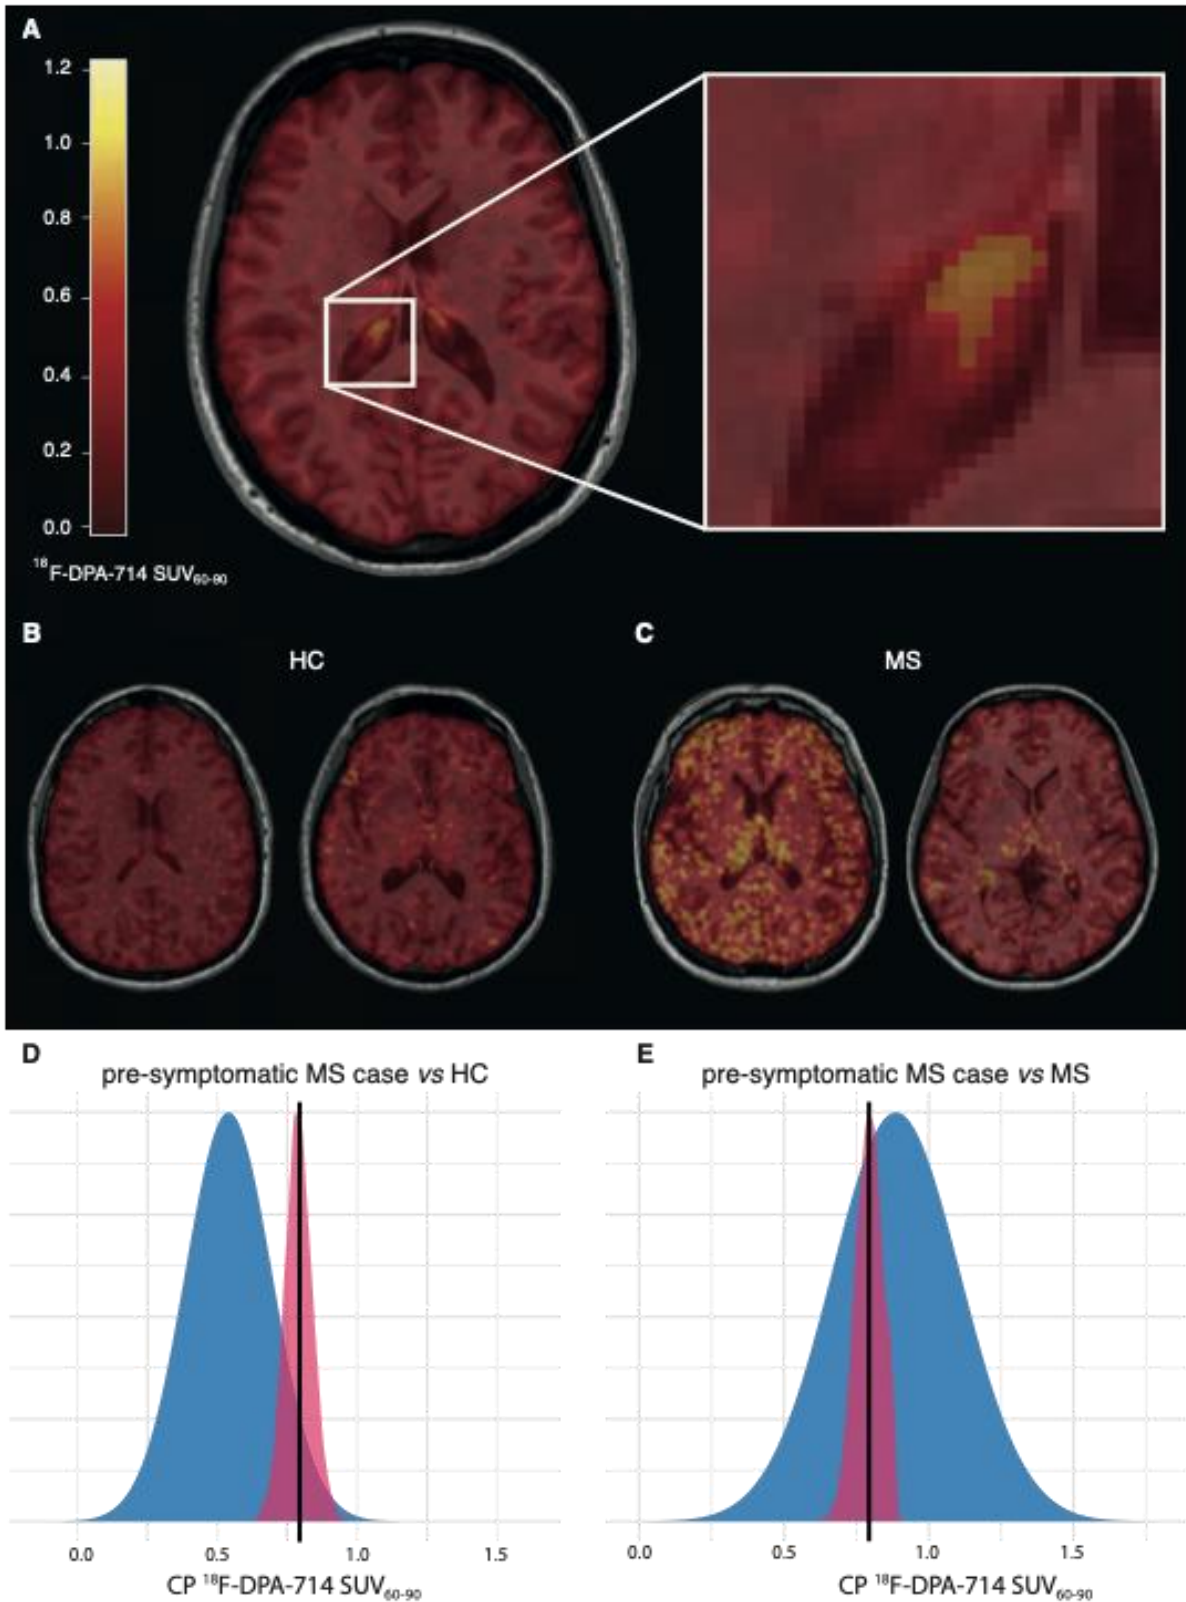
Higher $^{18}\text{F-DPA-714}$ uptake in the CPs of pre-symptomatic MS. A. Axial $^{18}\text{F-DPA-714 SUV}_{60-90}$ map registered onto the 3DT1-weighted MPRAGE image of the pre-symptomatic MS case, with the corresponding color bar (left), and magnification on the CP of the right lateral ventricle (right). B-C. Examples of axial $^{18}\text{F-DPA-714 SUV}_{60-90}$ maps
